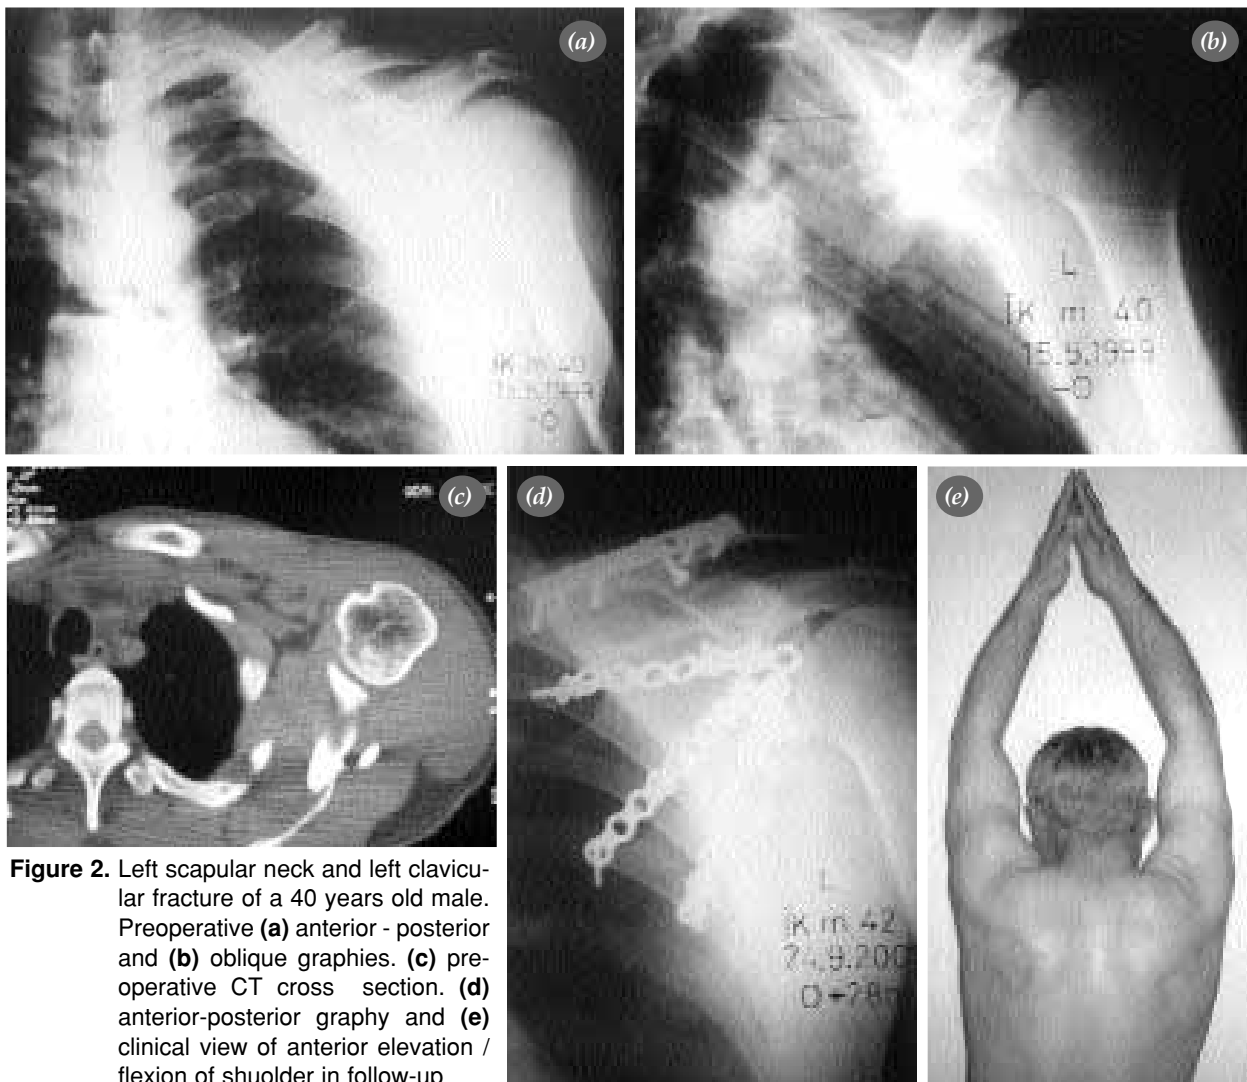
Left scapular neck and left clavicular fracture of a 40 years old male. Preoperative (a) anterior - posterior and (b) oblique graphies. (c) preoperative CT cross section. (d) anterior-posterior graphy and (e) clinical view of anterior elevation / flexion of shuolder in follow-up
